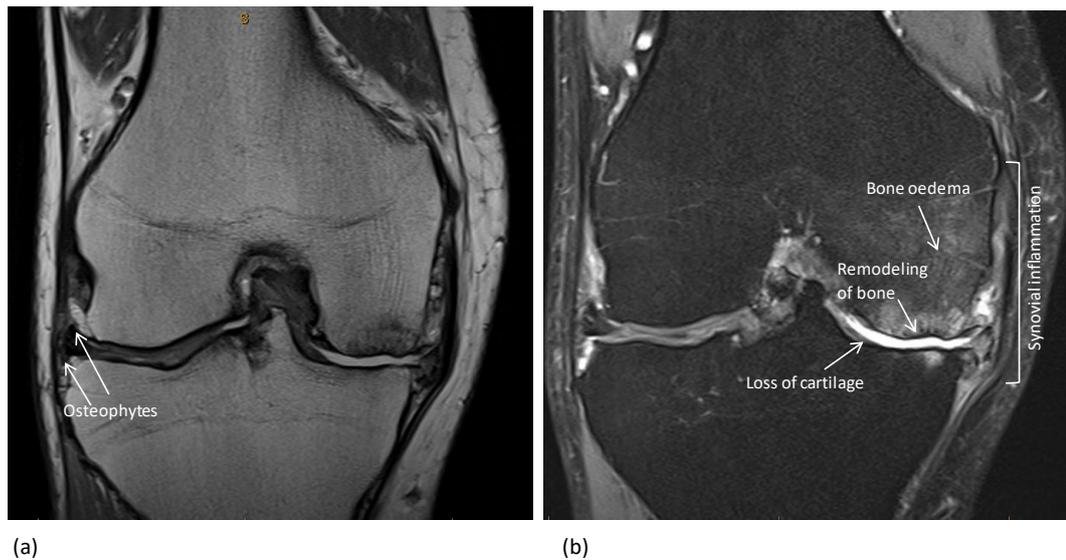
(a) T1 weighted MRI image and (b) T2 weighted MRI image showing some structural changes of OA knee.
